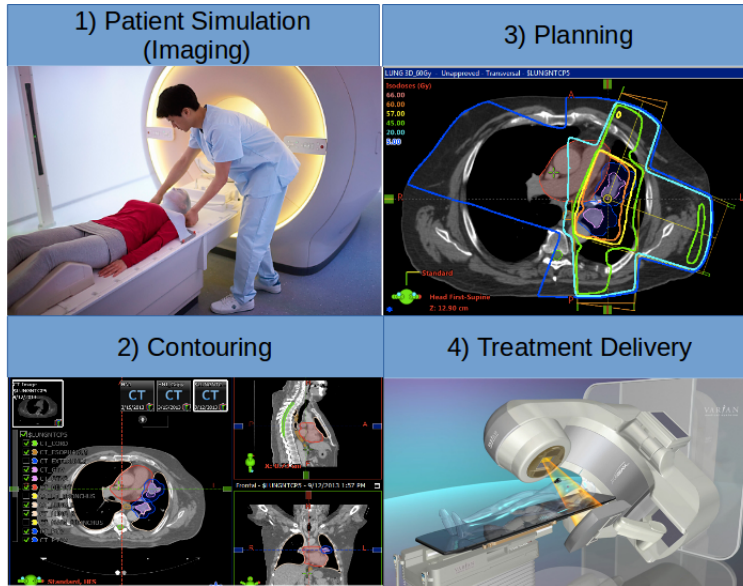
External beam RT treatment flow.^a 1) Patient is imaged via CT scan; 2) Physician manually contours important structures on 2D slices of the 3D image; 3) Treatment plan optimization is performed (shown in the picture are 2D slices depicting patient's anatomy and dose distribution); 4) Treatment is delivered using a linear accelerator that emits beams of radiation through a gantry.
